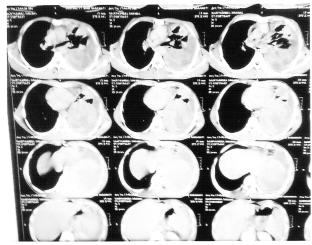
HRCT thorax showing left-sided mass (8cm x 9cm) with few necrotic areas, pleural effusion and partially collapsed left lung.
